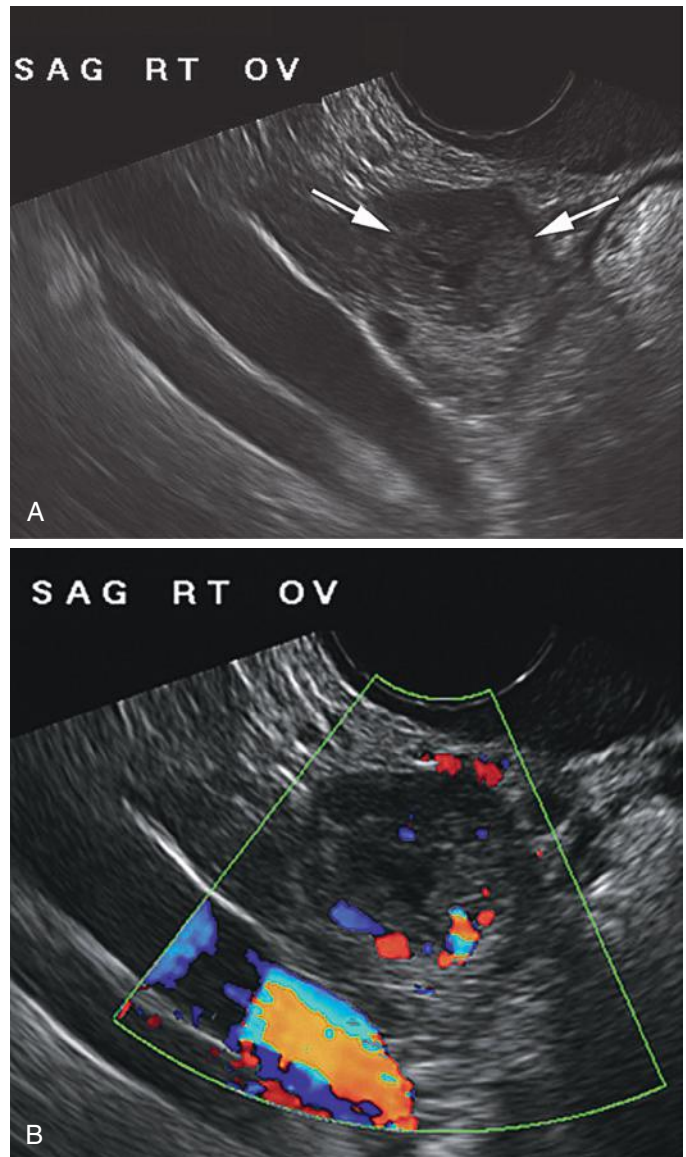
Corpus luteum. A, Sagittal gray-scale image of the right ovary, adjacent to the iliac artery and vein, shows a complex, hypoechoic thick-walled cyst (*arrows*) with the characteristic sonographic appearance of a corpus luteum. There is an adjacent small anechoic follicle posteriorly. B, Color Doppler sonographic image shows a prominent ring of peripheral vascularity at the outer edge of the thick-walled cyst, compatible with a corpus luteum.
